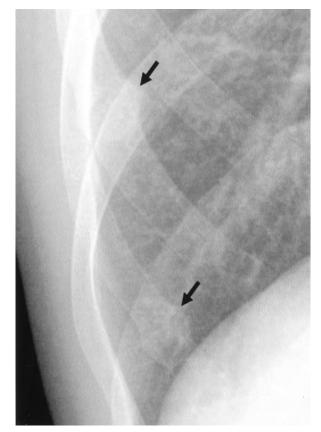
Plain radiography showing callus formation (arrow) on the right  $7^{th}$ , and  $8^{th}$  ribs.
